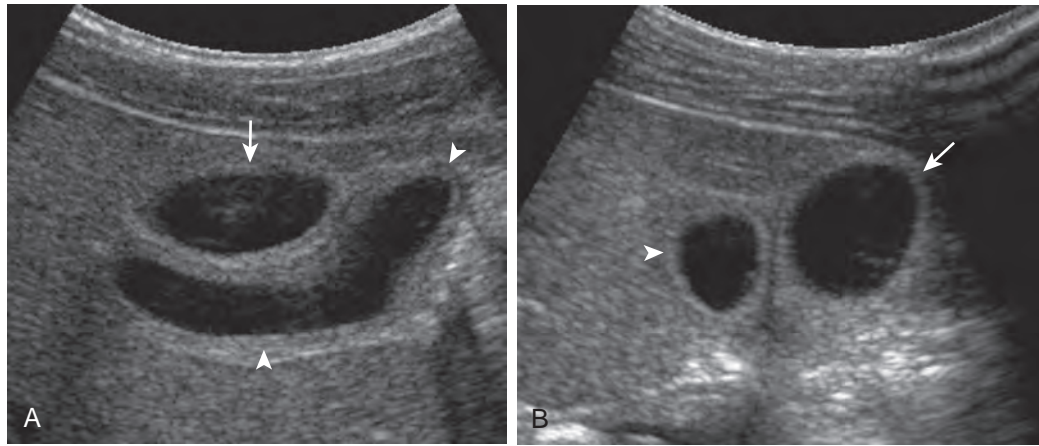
Duplication of the gallbladder. A and B. Sonograms in two planes demonstrate two gallbladders (arrows and arrowheads) in a 10-year-old child with biliary colic.
